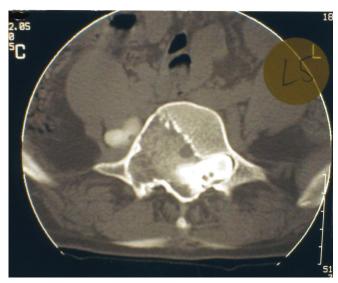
Axial T2WI MRI scan at the level of L5, demonstrating invasion and destruction of the right half of the vertebral body by the disease process.
